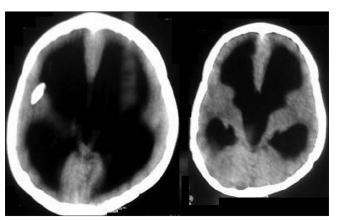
Preoperative CT scan shows moderate hydrocephalus and proximal shunt tube tip in the ventricle
